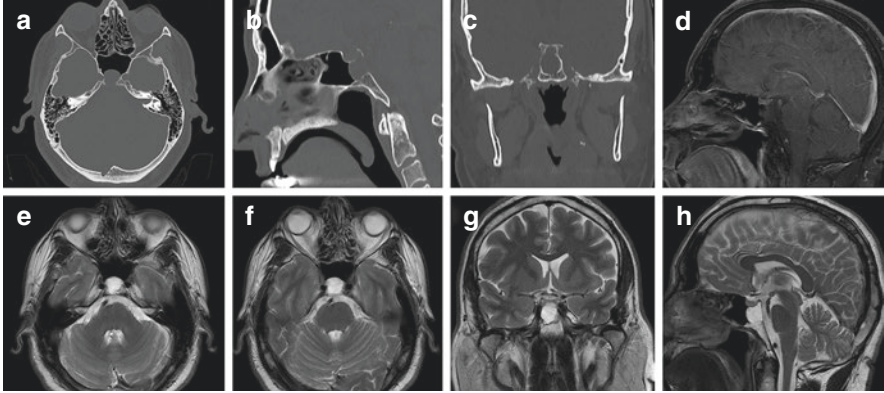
Clival chordoma with BNCT. Preoperative CT images (a–c) demonstrating the lesion. Preoperative sagittal T1-weighted MRI with contrast revealed no enhancement of the lesion (d). Hyperintense signal of the lesion is seen on T2-weighted images (e–h)
